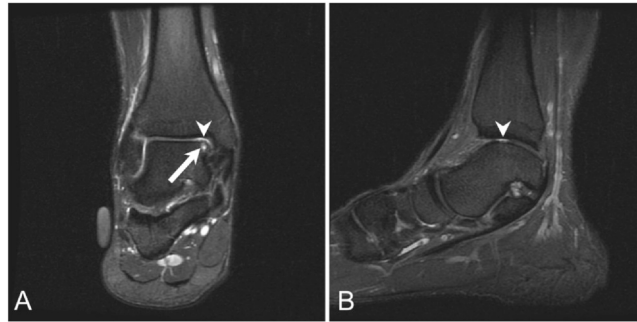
Elite football wide receiver with a history of recurrent ankle sprains in the past. Coronal T2 FS (A) and sagittal STIR (B) MR images show a small, stable OCL at the medial talar dome with accompanying mild subchondral bone marrow changes (arrow in A) and a reciprocal focal full-thickness cartilage defect at the medial tibial plafond (arrowhead in A and B). FS, fat saturation; MR, magnetic resonance; MRI, magnetic resonance imaging; OCL, osteochondral lesion; STIR, short tau inversion recovery.
